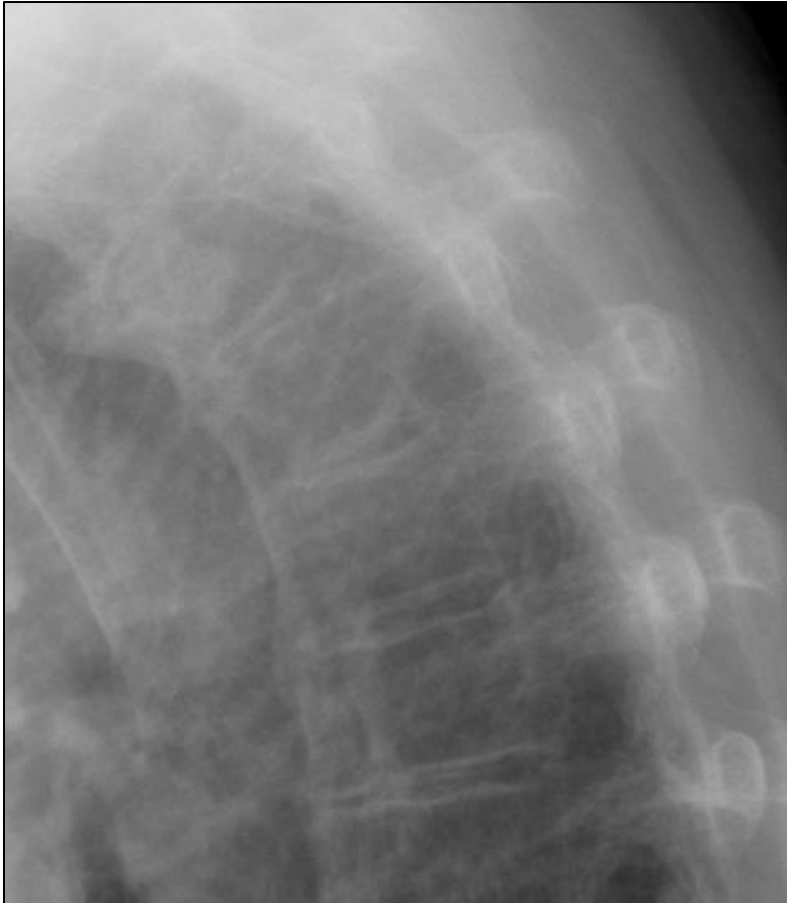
Fractures in patients with DISH. a. Sagittal reformatted CT showing a transdiscal fracture which is open anteriorly (black arrow). Compared to other levels, there is discontinuity of the ossified anterior longitudinal ligament. b. Sagittal T2-Weighted image of the same patient as in a confirms the transdiscal fracture extending into the posterior elements with disruption of the anterior (white arrow), posterior longitudinal, interspinous and supraspinous ligaments. There is a large fluid cleft in the disc space and a posterior epidural hematoma compressing the spinal cord with central myelomalacia. c. Sagittal reformatted CT in another patient showing a transvertebral fracture parallel to the endplate (white arrows). d-e Lateral radiograph of the thoracic spine (d) and spot view (e). This fracture was -even in retrospect- not visible on CR (same patient as in c).
